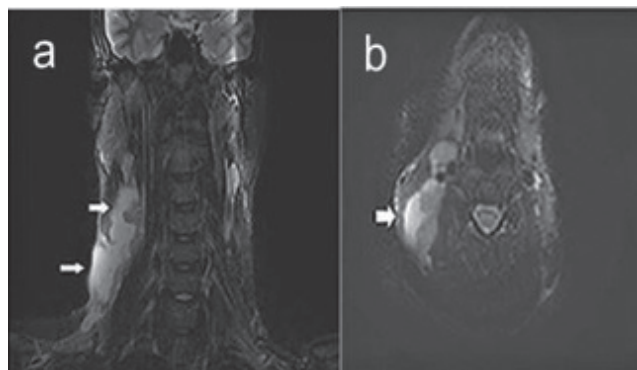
a-b: T2W coronal and axial MR images of the cervical region
